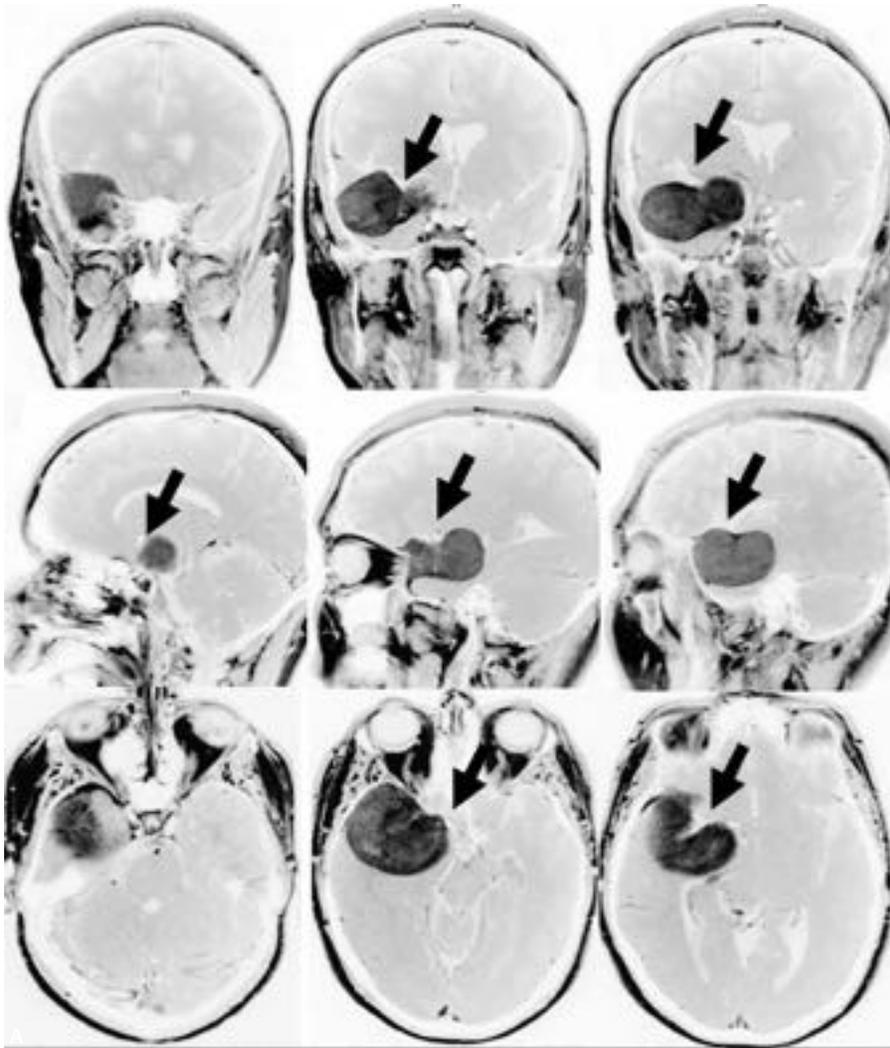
Large middle sphenoid wing meningioma. The patient was a 41-year-old woman who presented with a generalized seizure. (A) The size and location of the tumor are well delineated by triplanar T1-weighted magnetic resonance imaging. There is only minimal dural involvement. The course of the carotid and the middle cerebral artery and its branches are visible (*arrows*). Tumors of this size may encroach upon and compress the optic apparatus (for comparison see Figs. 23.6 and 23.9: optic nerve compression from dural and intraosseous growth). (B) The vascular relations (*arrows*) are depicted even more clearly on T2-weighted images. (C) At surgery the tumor was found to originate from the middle sphenoid ridge (i.e., this tumor is not a medial wing [clinoidal] meningioma with a large lateral component). Pamir et al have pointed out that clinoidal meningiomas usually infiltrate the bone of the anterior clinoid process.¹⁶ There was no bone infiltration in this case. Copyright M. Simon and J. Schramm, reproduced with permission.
